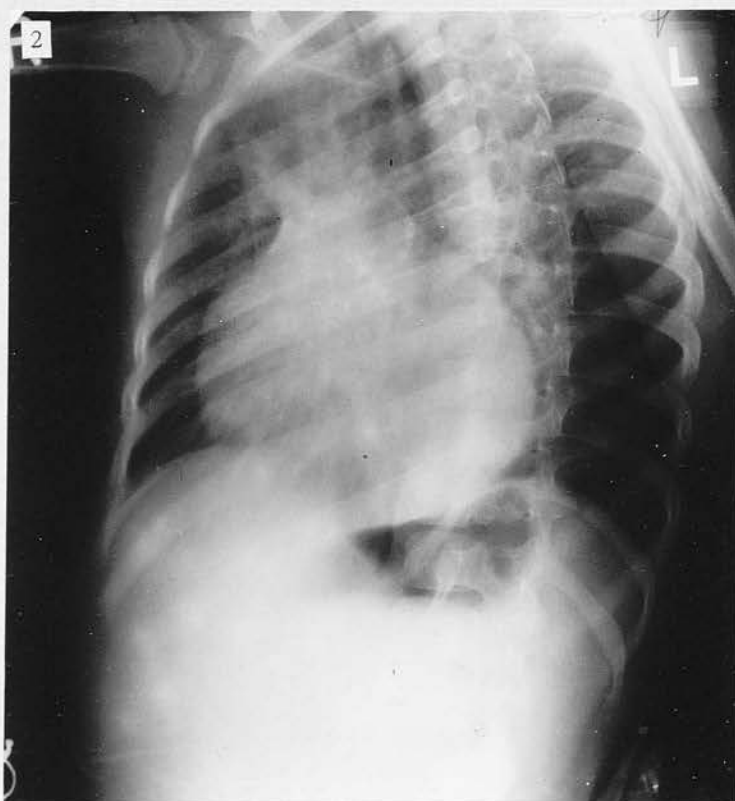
Radiograph of Case 105. Early cardiac enlargement with unusual degree of L.V. enlargement at 4yrs.
